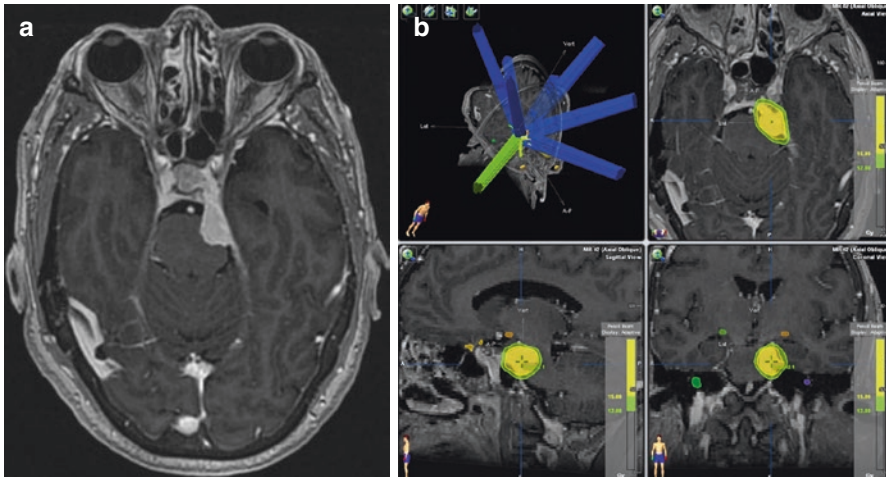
Left cavernous sinus meningioma. (a) MRI before SRS. (b) Treatment plan SRS, Dose prescription 15 Gy periphery
